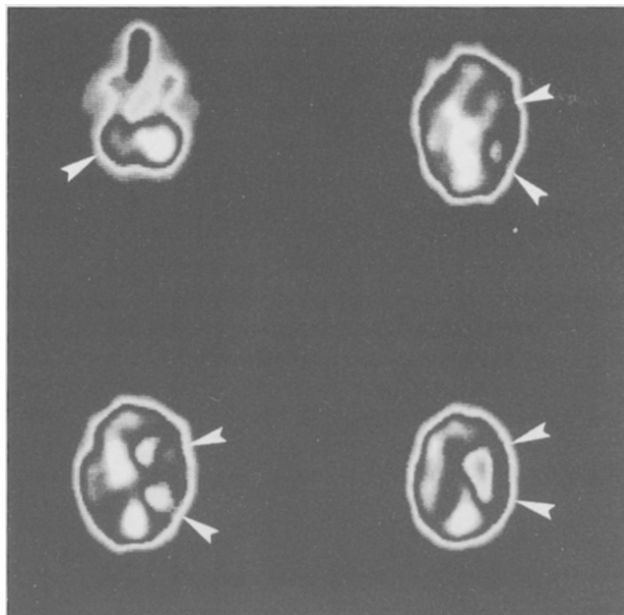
(c) — Case 2, SPECT study in chronic stage: severe cortical and subcortical hypoperfusion in the right hemisphere (arrows).
